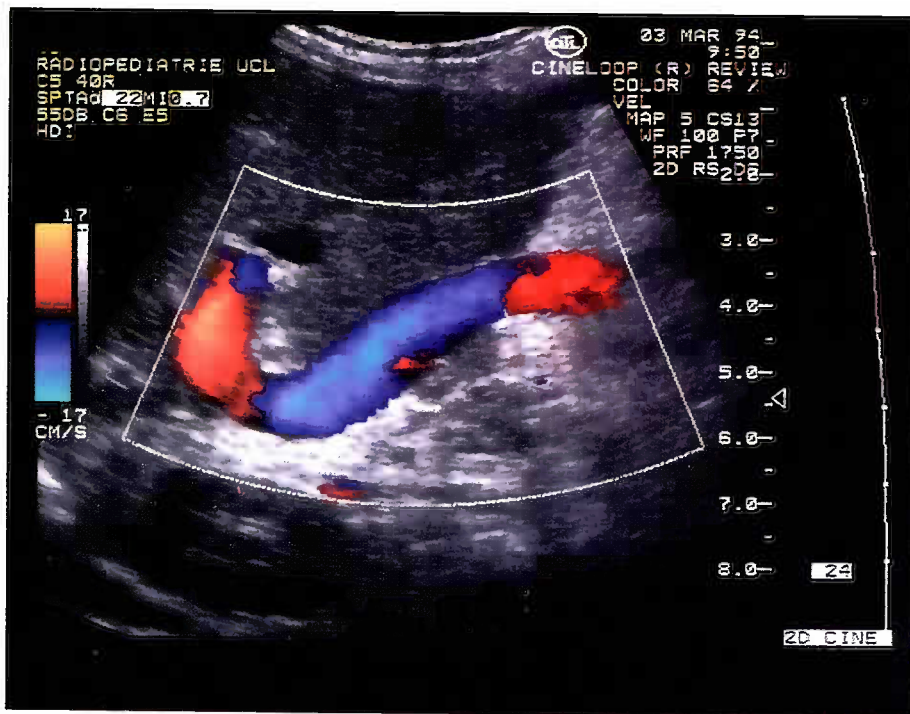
Doppler Ultrasound of the portal vein in a segmental graft: the vein runs harmoniously below the graft with a right sided J shape before entering the parenchyma.
